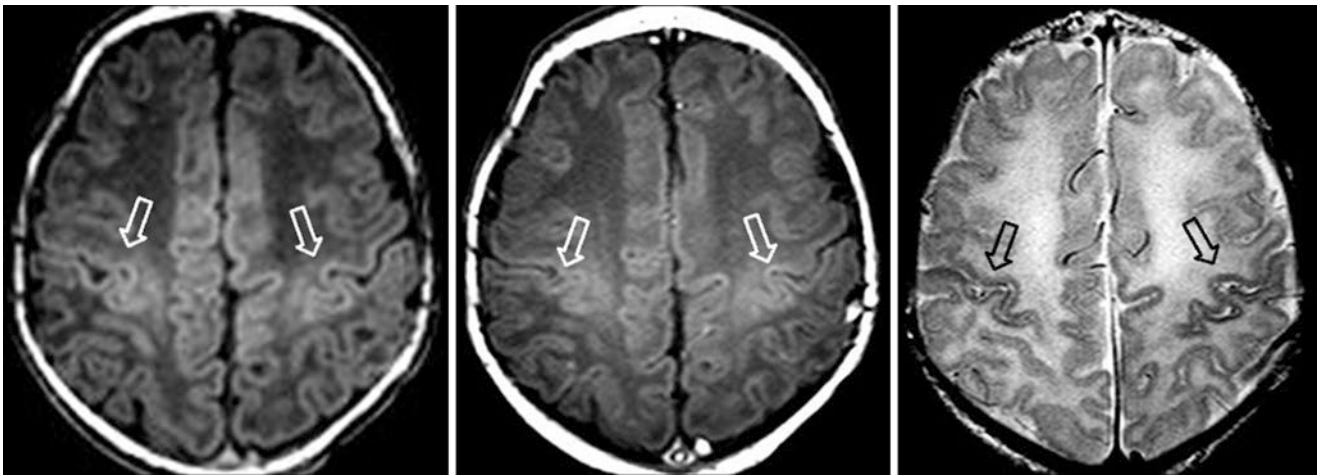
A 6-day-old term neonate had a normal 3T MRI with GE T1WI (*left*), SE T1WI (*left middle*), and SE T2WI (*right*). The PRC (*open arrows*) is visualized as slightly bright on GE T1WI, but clearly
